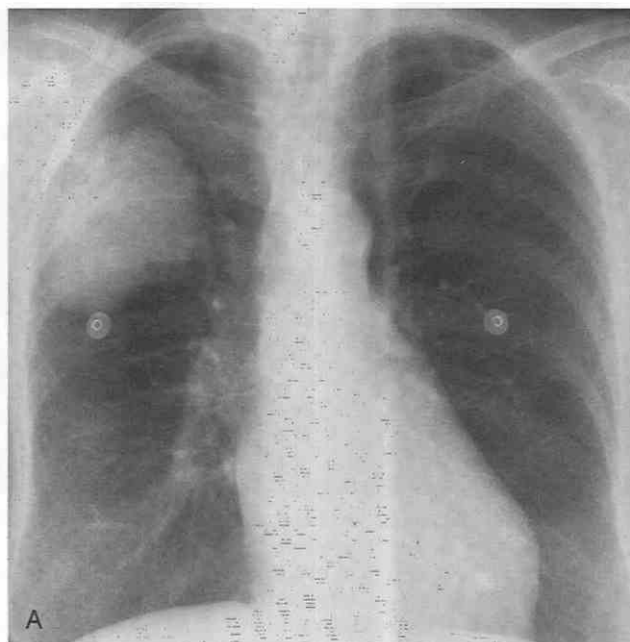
Squamous cell lung cancer manifesting as a peripheral mass. A, Posteroanterior chest radiograph shows a large lobular mass in the right upper lobe. Note the absence of hilar or mediastinal adenopathy. B, CT confirms the large lobular mass in the right upper lobe.
